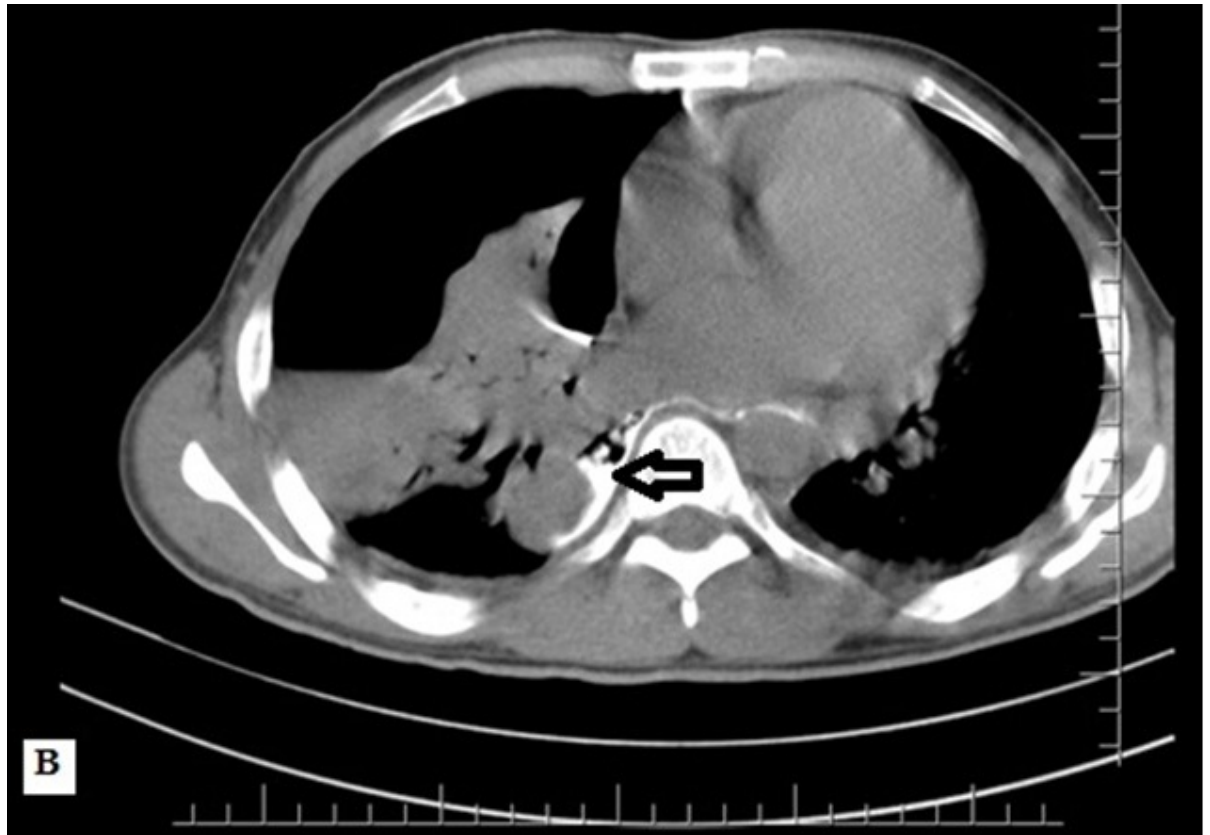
CT scan thorax showing contrast leak (Black arrow)
